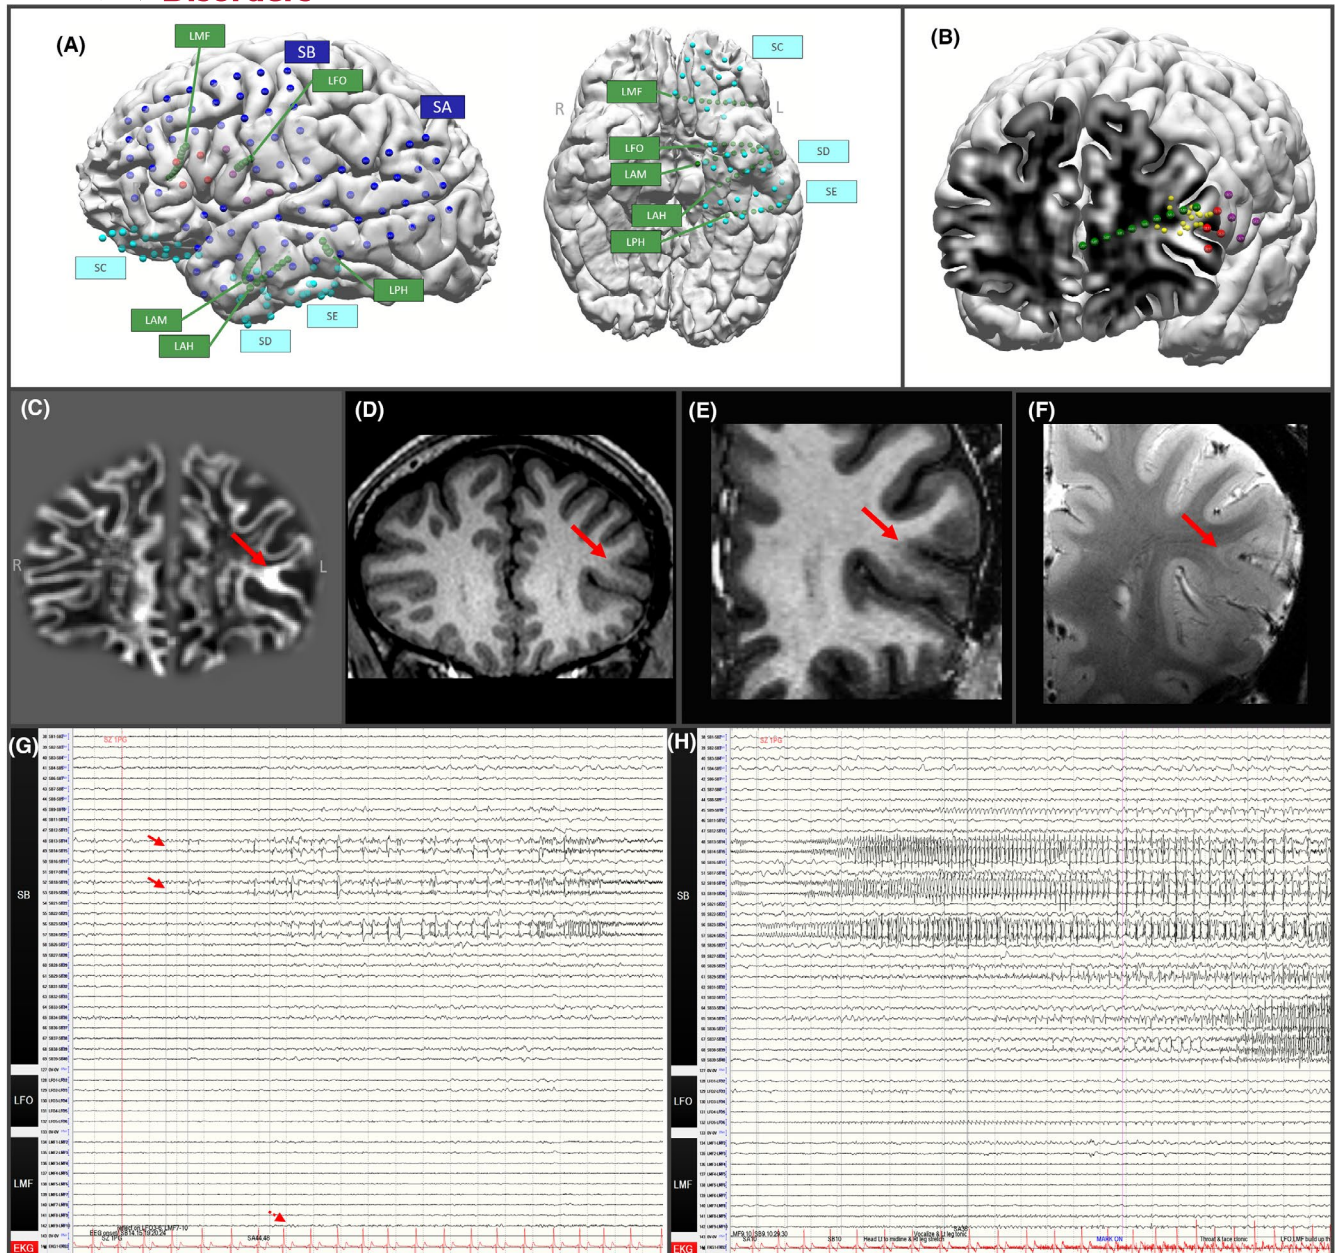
Case 2: Intracranial EEG data from the initial evaluation and data for reevaluation. (A) 3D-reconstruction of subdural grids (blue), strips (light blue), and depth electrodes (green) placement in the left hemisphere. (B) Multimodal integration of 3D cortical surface, MAP junction file showing the bottom-of-sulcus lesion, with pertinent electrodes from the previous invasive evaluation. Cut plane corresponds to the subtle lesion detected by MAP. For A and B, colors of spheres are as follows: Red = contacts at seizure onset; Yellow = MEG dipoles; Purple = contacts with speech disturbances during cortical stimulation. (C) Coronal view of MAP gray-white junction file based on 3T T1w MRI (shown in D), highlighting the subtle abnormality in the left inferior frontal region. (D) Coronal 3T T1w image at the same slice of (C). (E) Zoomed in view of the subtle abnormality on coronal 7T T1w MP2RAGE image. (F) Zoom in view of the subtle abnormality on coronal 7T T2* GRE image. (G, H) Intracranial EEG tracing at the onset (G), and 15s of seizure (H) arising from the left inferior frontal region (SB 14–15, 19–20, red arrows). The closest depth electrode to the subtle abnormality was LMF, and low-voltage fast activities were seen on the lateral contacts of LMF (dashed arrow), later than the onset.
